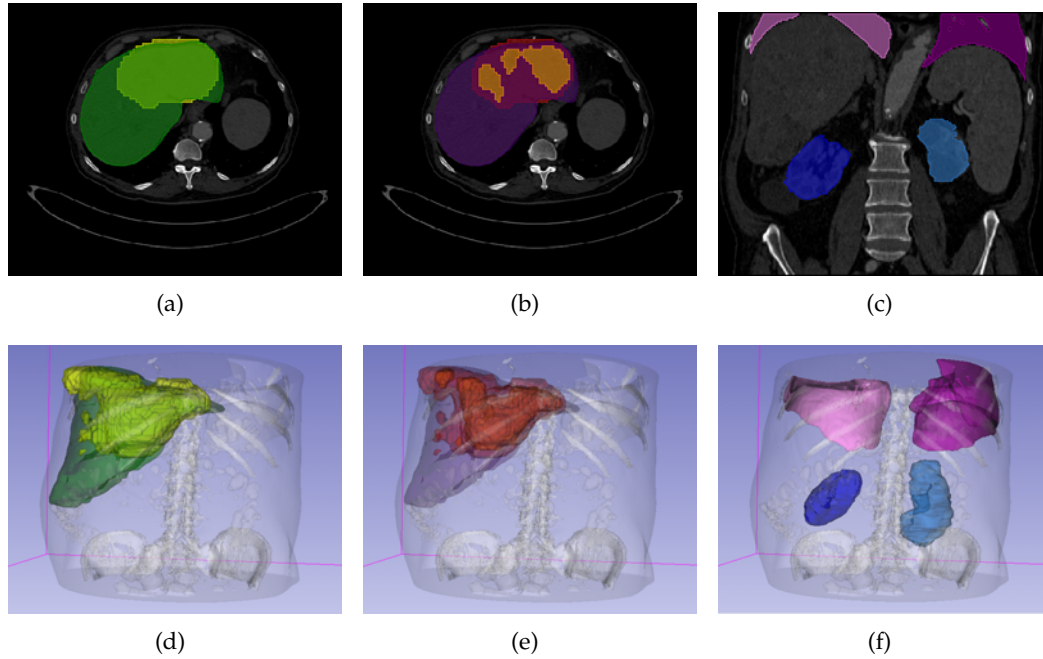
Representation of the defined VOIs on axial (a,b) and coronal (c) native CT slices and in 3D view (d, e, f). The color-VOI key is: green = liver, yellow = liver perfused, orange = lesions, red = healthy liver perfused, violet = healthy liver, pink = right lung, magenta = left lung, blue = right kidney, light blue = left kidney.
